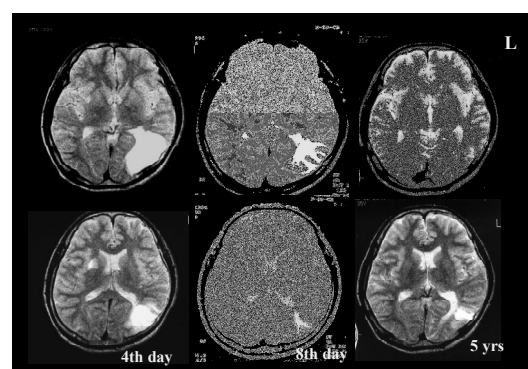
MRI of the brain in Case 1 with blurred vision
